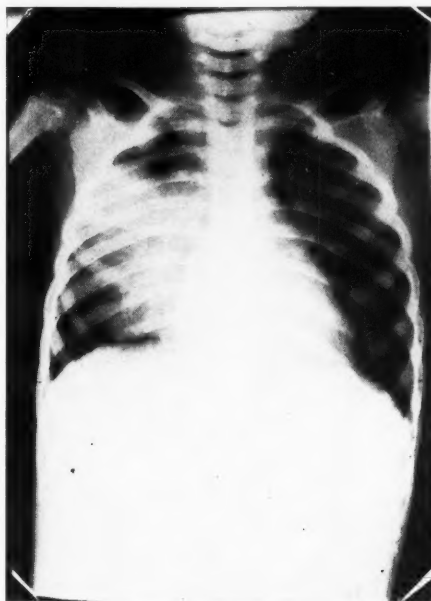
Case 1. Roentgenogram of F. V. L., female, aged three, lobar pneumonia. Film made Sept. 25, 1937, four days after entering hospital, about ten days after onset of illness. Greater portion of right middle lung-field consolidated; no specific type of sputum demonstrated. X-ray therapy with bedside unit began day after this film was made. (See Chart 1.)
